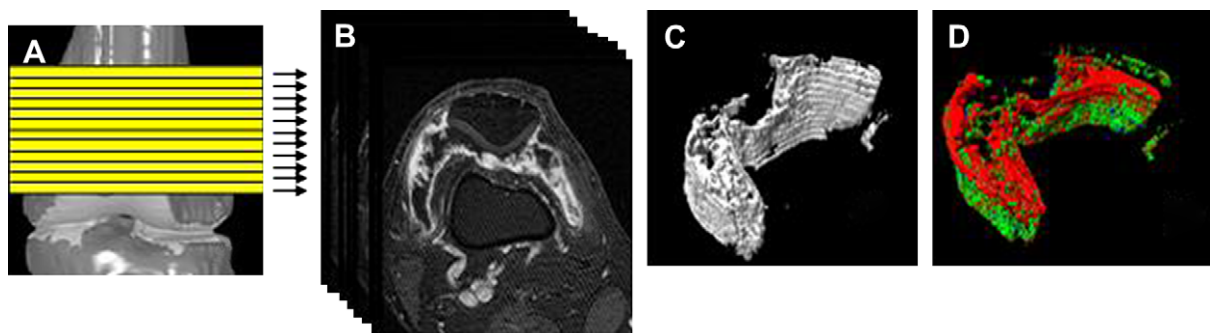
Only axial post-injection T1-weighted slices in which the patella was visualized were selected for volume analysis (A, B). On each slice, SM with a threshold of enhancement 45% was outlined and the SMV calculated (C). Finally the SMV was assessed according to its speed of enhancement and categorized as: low (blue colour), intermediate (green colour) or high speed of enhancement (red colour) (D). 254×190 mm (72×72 DPI).
